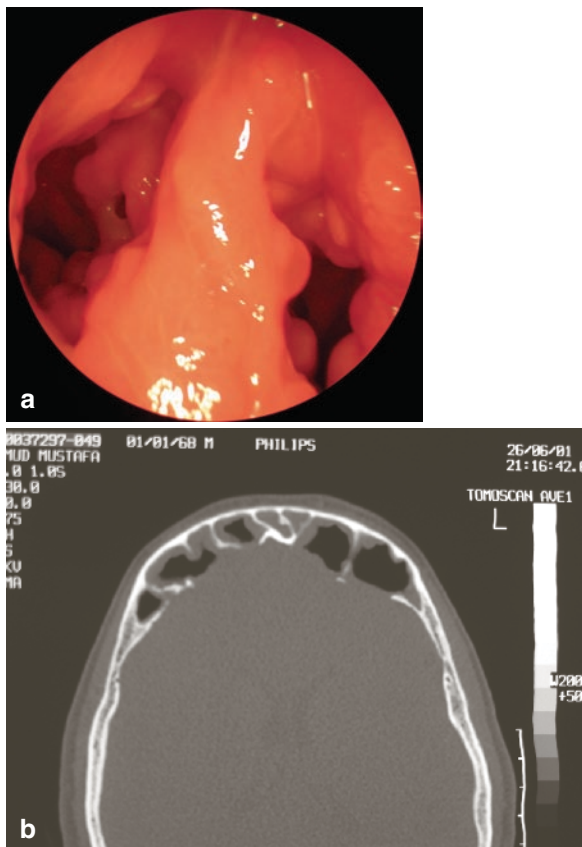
Six months following surgery with polypoid mucosa of the frontal sinus; (a) polyps in the frontal sinus, (b) axial CT
